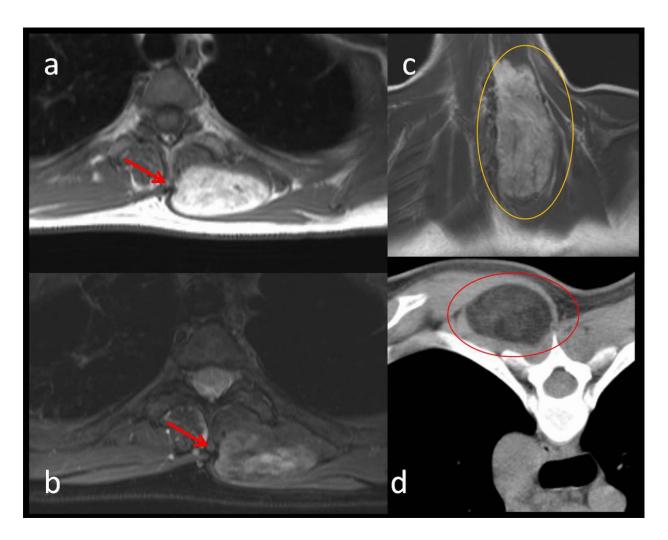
MRI reveals a heterogeneous nodule (arrows) with hyperintensity in T1-weighted MR images and loss of signal in T2-FS image. During CT performed for guiding biopsy (note prone position) the fat component in this tumor was also identified, with a slightly increased attenuation.
